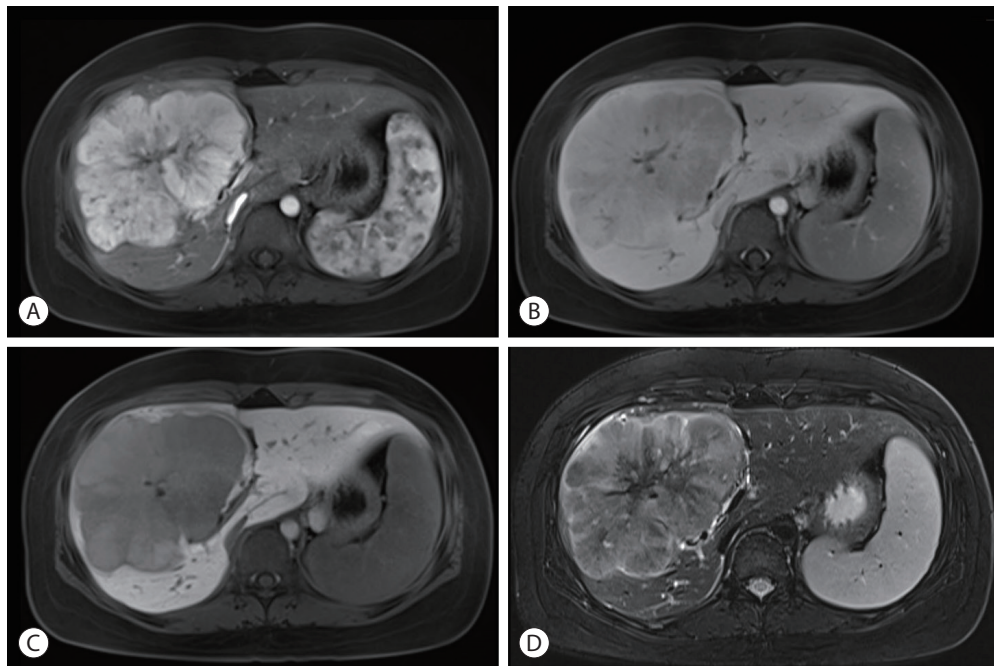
Liver dynamic magnetic resonance imaging showed 13 cm sized lobulated iso-signal intensity mass in the right anterior section with prominent arterial enhancement (A) and low signal intensity in delayed phase (B), defect in hepatobiliary phase (C), and a central scar on T2 weighted image (D).
